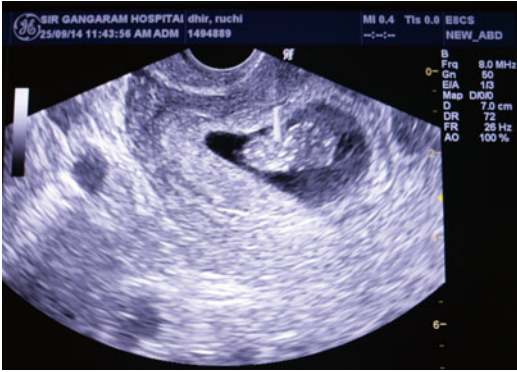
Ultrasonography showing transvaginal fetal reduction by injecting intracardiac potassium chloride
